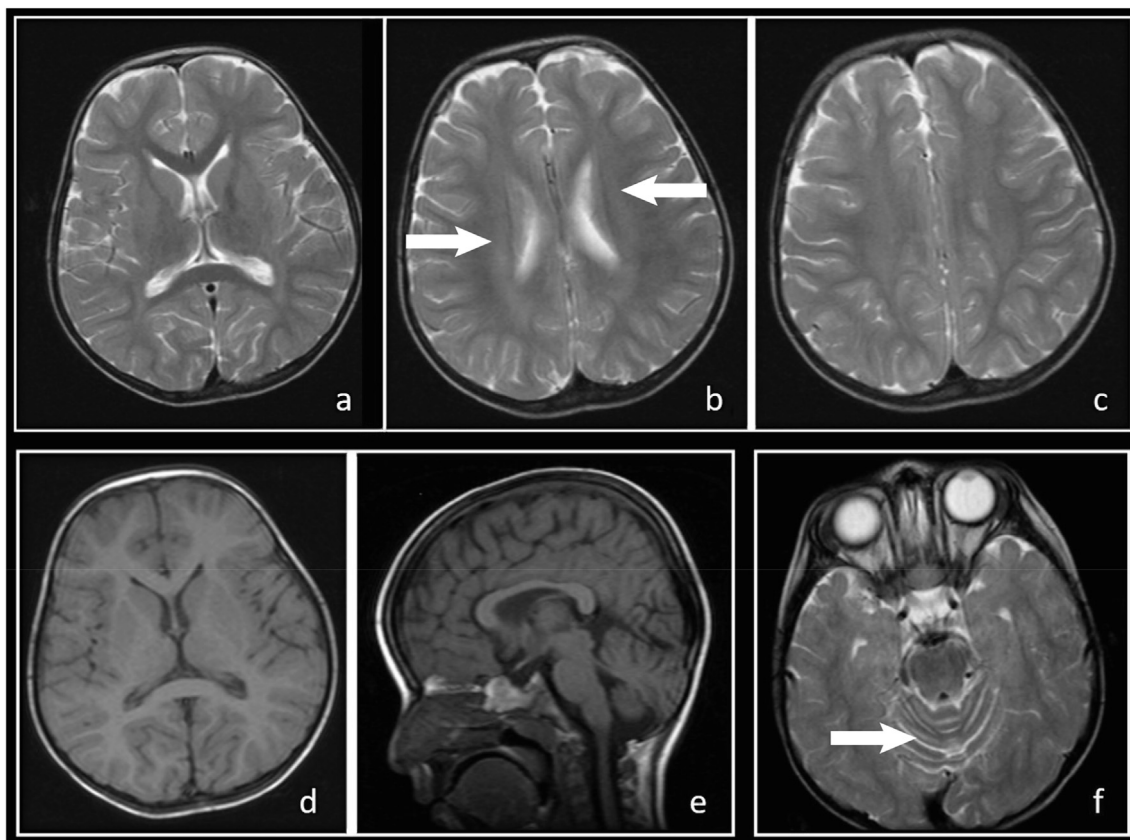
Patient 2 – T2-weighted axial sections (a, b, c, f), T1-weighted axial section (d) and T1-weighted sagittal section (e) from an MRI scan taken after the first seizure. Linear hyperintensity of central white matter can be seen (b), and prominent cerebellar folia, indicating mild cerebellar atrophy, is clearly demonstrated (f).
